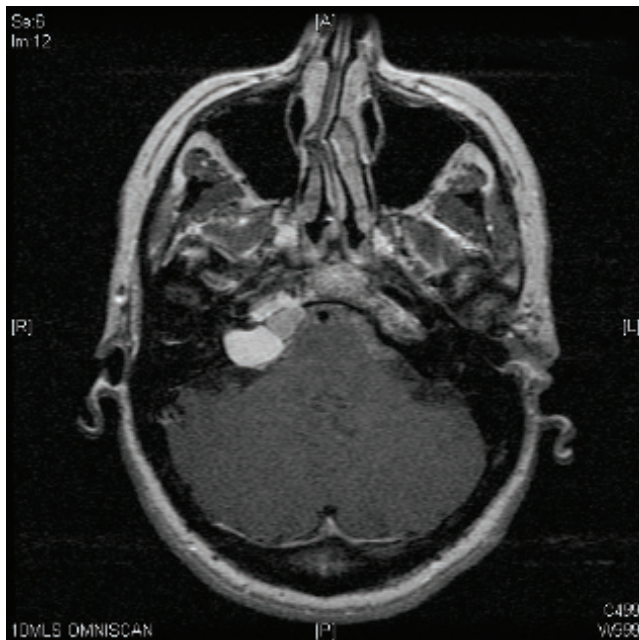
Axial T1-weighted MRI scan showing a right petrous apex cholesterol granuloma.
